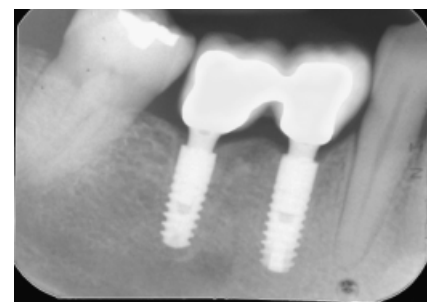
Test case: periapical radiograph taken 3 years after surgery.
